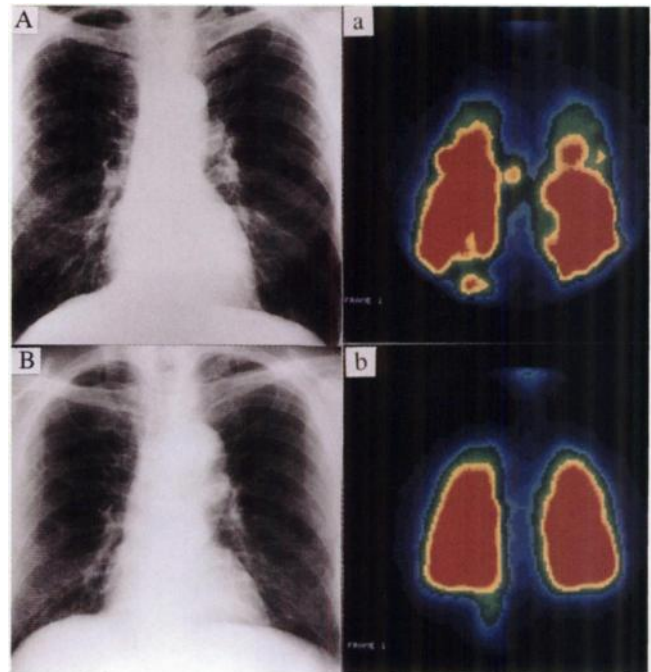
Chest radiograph and aerosol inhalation cine-sцинтиграм before and after erythromycin therapy in Patient 8, a 65-yr-old man with a response score of 9. Inhomogeneous pulmonary distribution of radioactive aerosols equalized, hot spots disappeared and chest radiographic findings improved.
